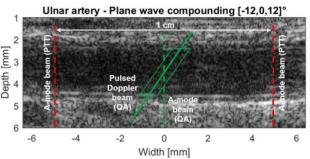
Principles of local PWV measurement methods on a longitudinal artery ultrasonic scan. In red, two A-mode RF-lines are used to measure the pulse transit time (PTT method). In green, one A-mode line measures the diameter of the artery over time and a pulsed Doppler sequence measures the blood flow in order to plot the flow-section curve (QA method).
